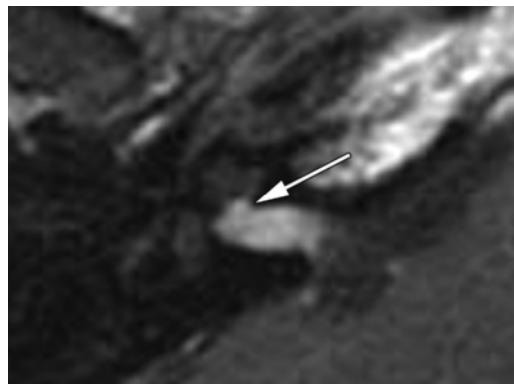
Tumor extending into the base of the modiolus. Axial contrast-enhanced fat-suppressed T1-weighted MR image (magnified view of the right petrous bone) shows an enhancing schwannoma at the fundus of the right IAC that extends into the base of the modiolus (arrow). Far lateral tumors complicate cochlear nerve dissection with all hearing preservation techniques—particularly the suboccipital approach, which involves limited lateral IAC exposure.
